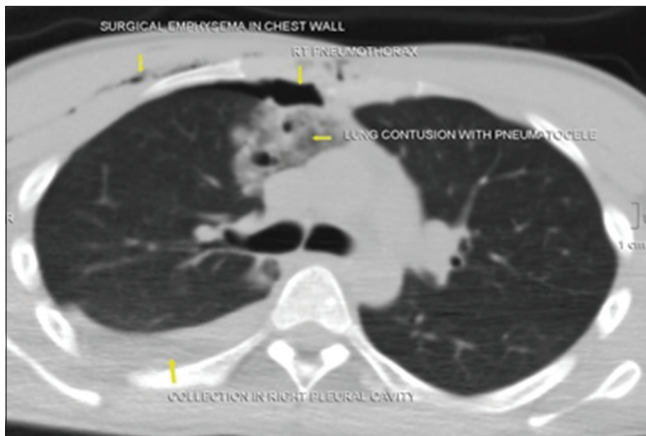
Non-contrast computed tomography chest axial view in a patient with blunt trauma to chest demonstrates pulmonary contusion in the right lung, right hemopneumothorax, and subcutaneous emphysema in the right chest wall
